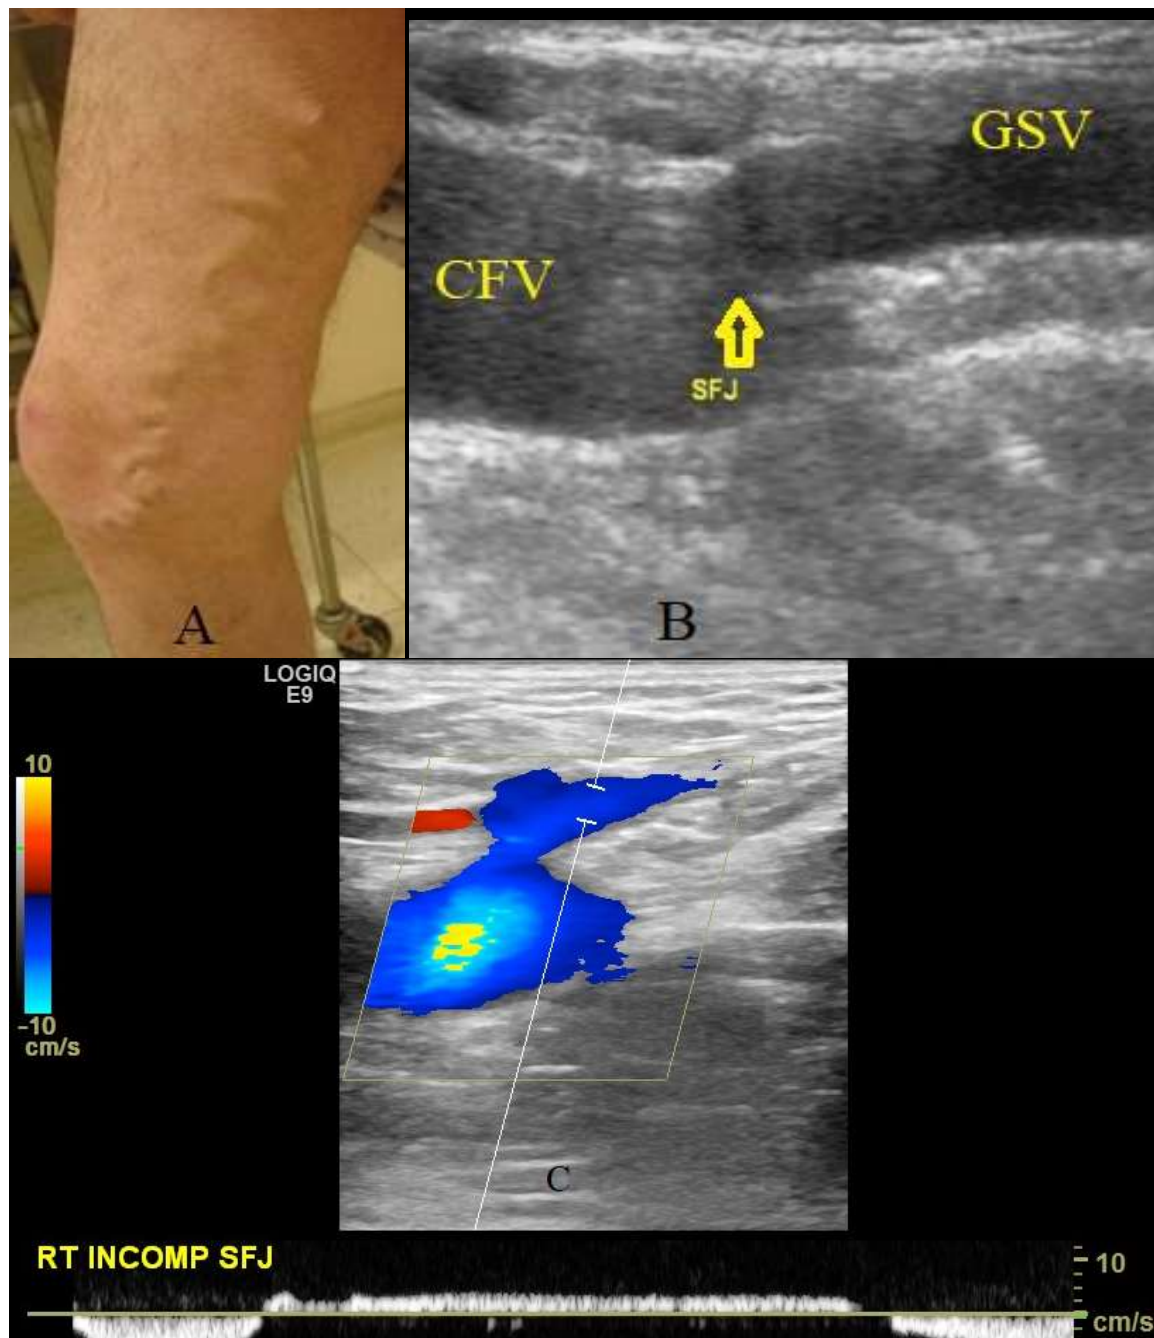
Color Doppler ultrasound .a-c A male patient of 45 years old presented with venous insufficiency symptoms a) the Right knee shows significant varicose veins along the medial aspect suggestive of great saphenous vein (GSV) reflux b) ultrasound showing the saphenofemoral junction(c) shows reflux with the Valsalva maneuver on Color Doppler examination .
